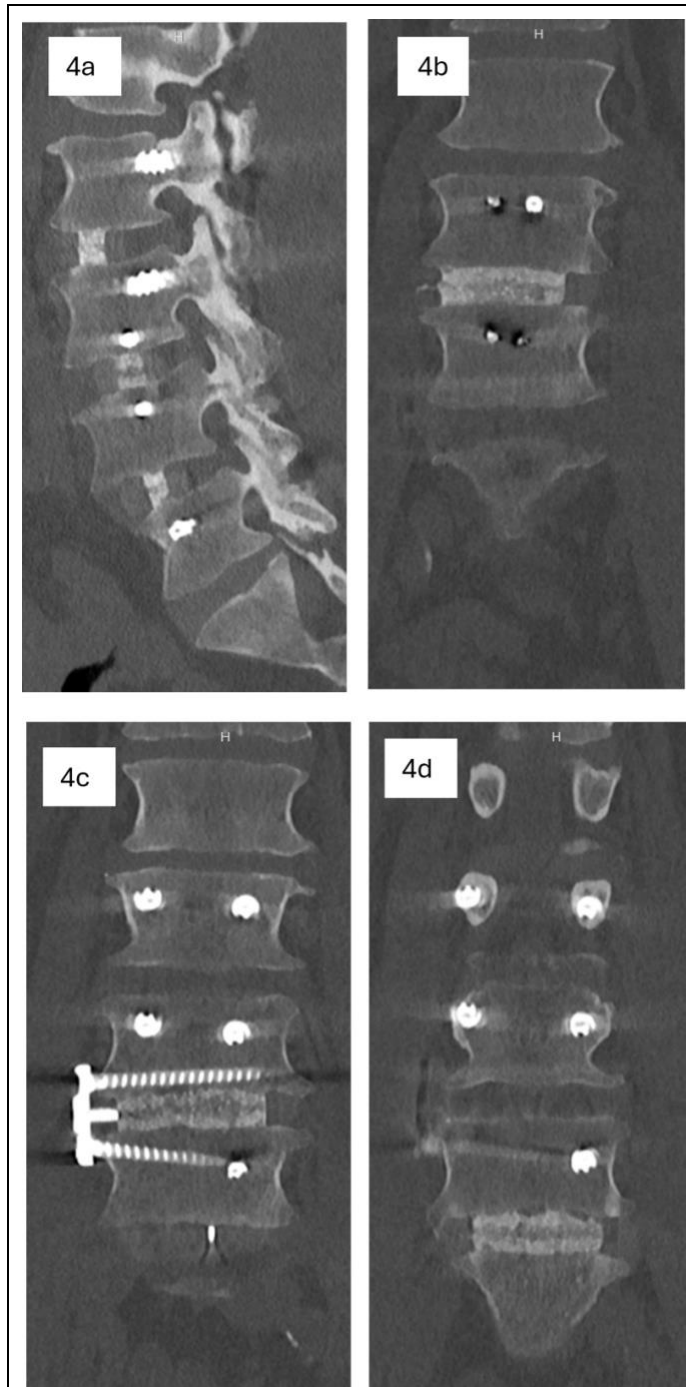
Complete bridging at L2-L3, L3-L4, and L4-L5 at 12-month follow-up: sagittal CT (a) and coronal CT reformations demonstrate continuous trabecular bone bridging with endplate-to-endplate bone incorporation at L2-L3 (b), L3-L4 (d), and L4-L5 (c).
